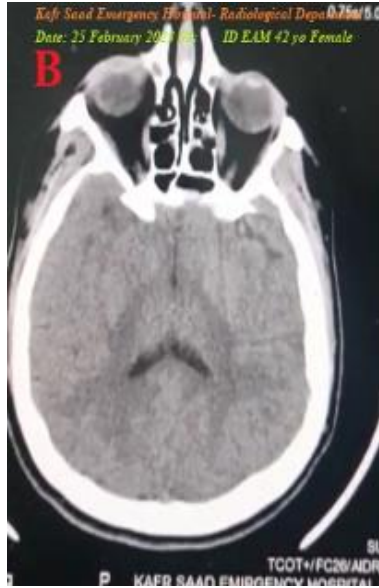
Brain CT was normal
